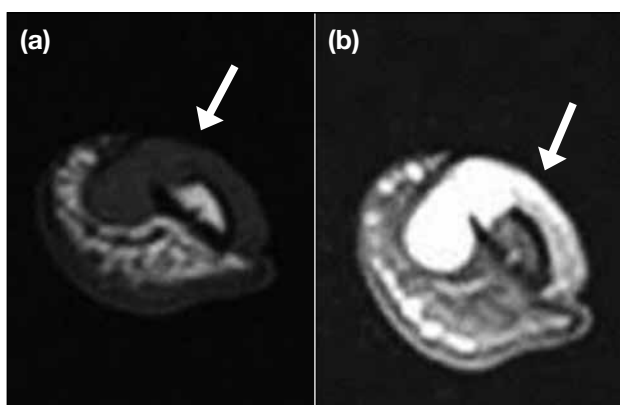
Glomus tumour in a 23-year-old man who presented with a 10-year history of left thumb mass: (a) T1-weighted axial magnetic resonance image showing a hypointense lobulated mass (arrow) over the dorsal aspect of distal phalanx of the thumb, lying underneath the nail plate of the distal phalanx. Erosion of underlying bone over the ulnar aspect is suspected. (b) T1-weighted post-contrast fat-saturated axial magnetic resonance image showing there is nearly homogeneous contrast enhancement.
